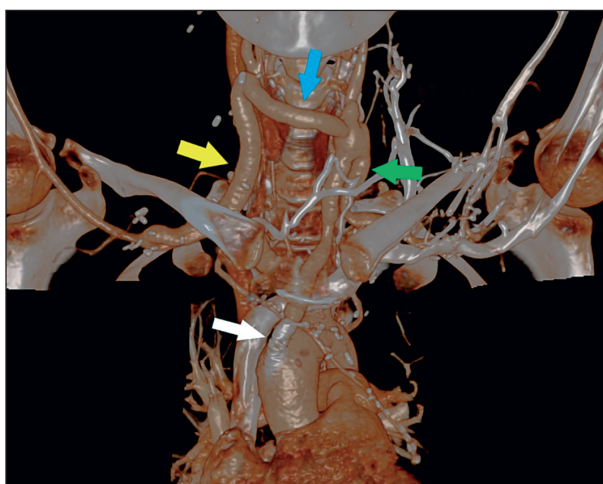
CT angiography – bilateral subocclusion/stenosis of common carotid artery (ACC), and left subclavian artery. Bypass from ascending aorta to the left ACC and stent placement into the stenotic part (white arrow). Bypass from the left ACC to the left axillary artery (green arrow), bypass between right and left ACC (blue arrow), bypass from the right subclavian artery to the right ACC (yellow arrow).
